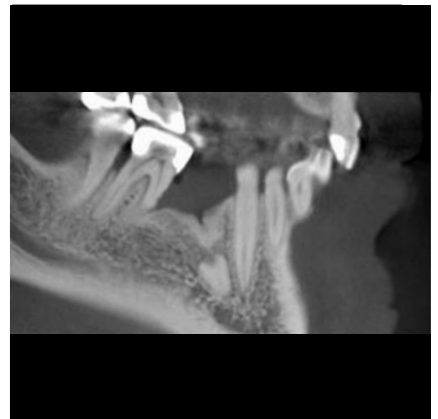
Sagittal CBCT image
